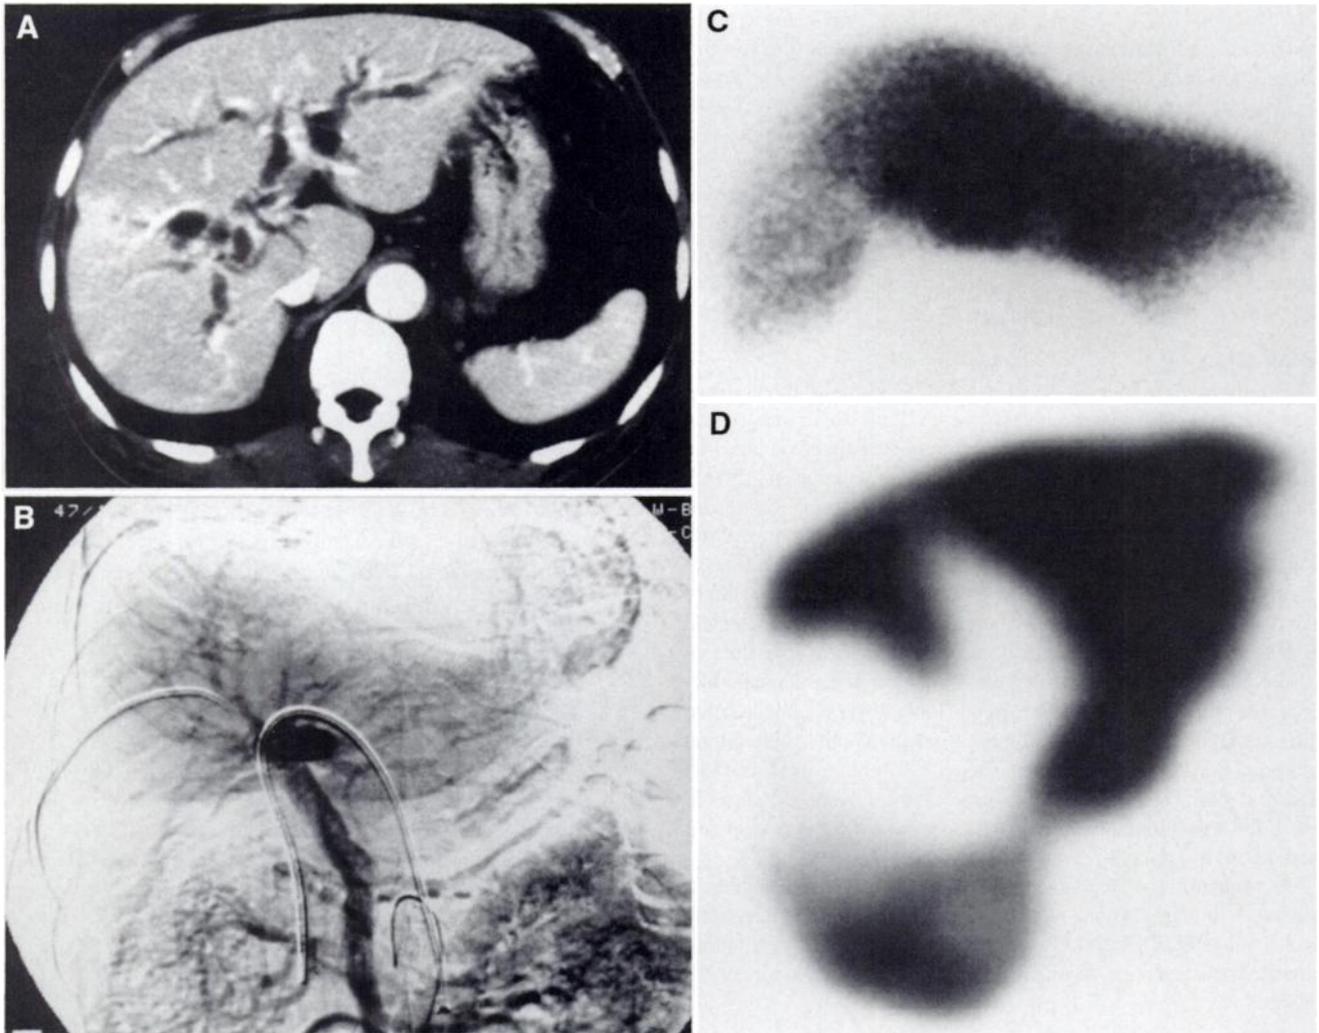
66-y-old man with hilar cholangiocarcinoma. (A) Enhanced CT scan shows symmetric intrahepatic bile duct dilatation. Right hepatic lobe is atrophic to some degree. (B) Portogram via superior mesenteric artery shows obstruction of right portal vein. Portal venous perfusion is markedly decreased in right lobe. Right anterior oblique (C) and transaxial (D) SPECT images show obvious decrease in ^{99m}Tc -GSA accumulation in right lobe.
